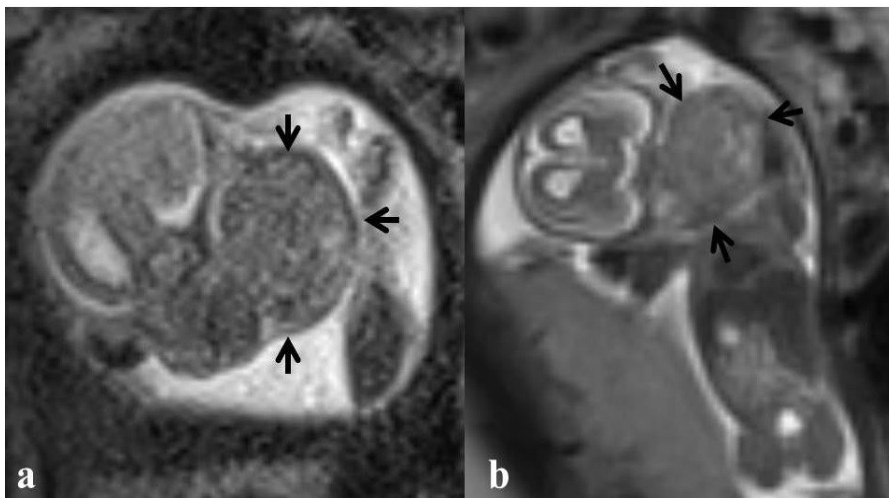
T2-weighted MRI is demonstrating tumor-like mass which compress adjacent structures on axial (a) and sagittal (b) planes.
